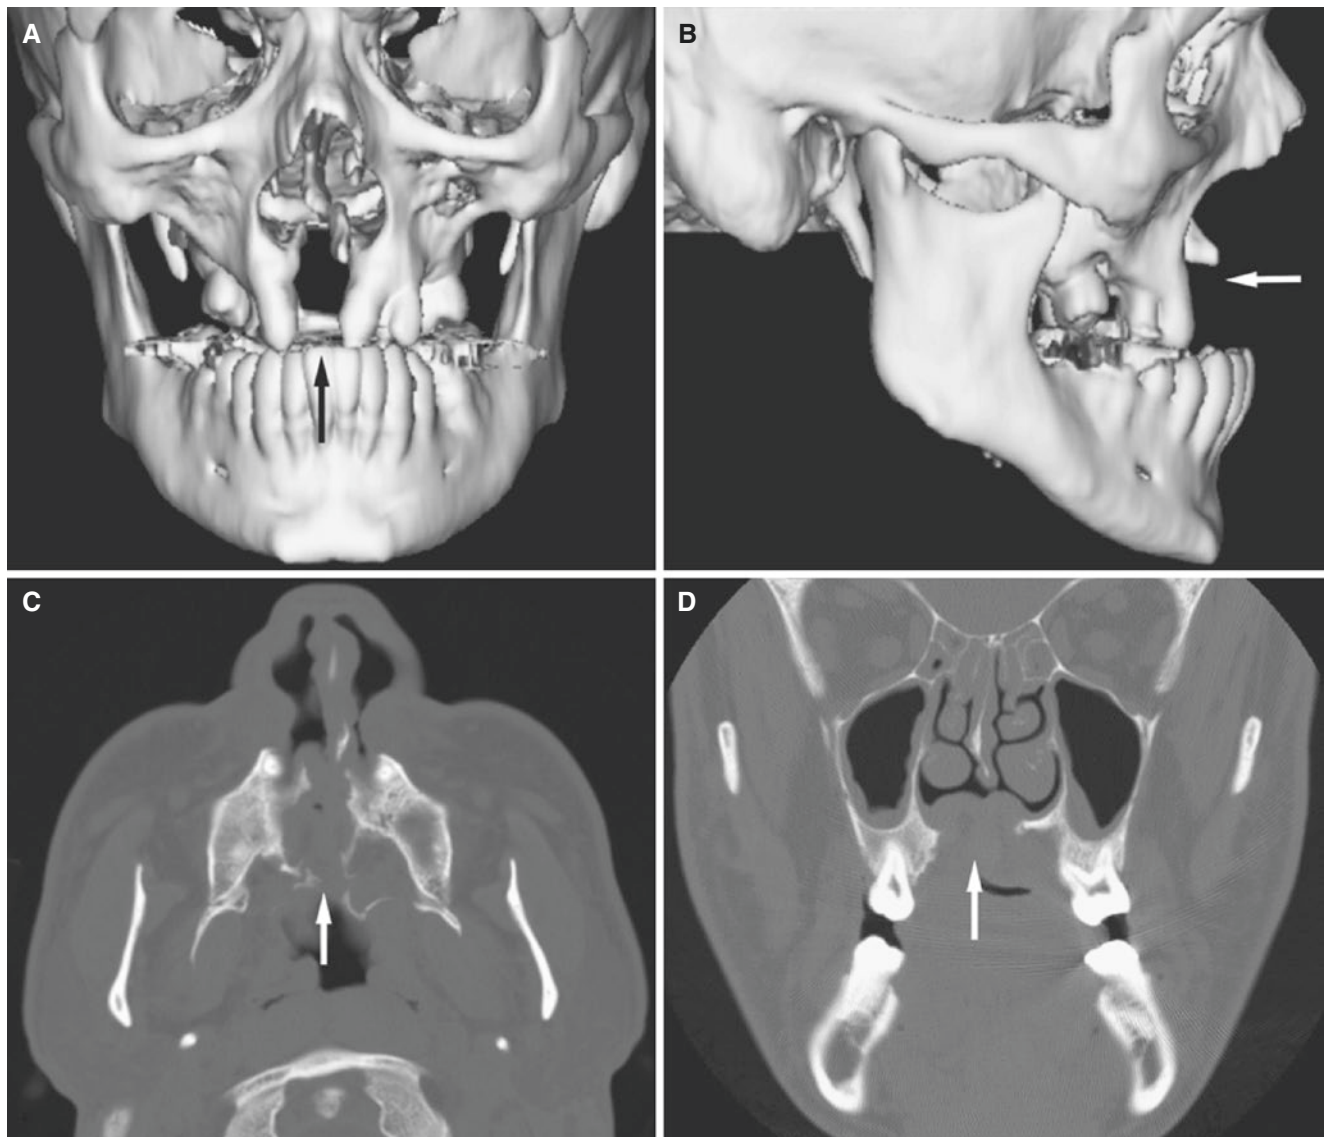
Cleft palate, midline; 31-year-old male with untreated deformity. (A) 3D CT image, en face view, shows almost symmetric cleft (*arrow*) with premaxillary segment and incisors absent. Narrow nasal bone. (B) 3D CT image, lateral view, shows hypoplastic maxilla
